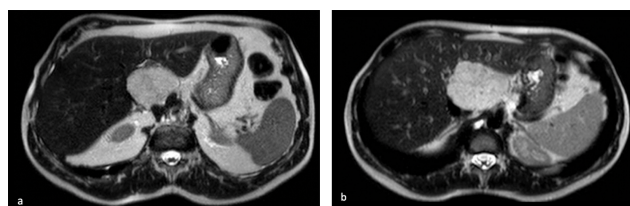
Preoperative CT-scan. (a) Case 1 MRI showing a GLH of CL (89 mm × 59 mm × 52 mm) in contact with IVC and the portal vein. (b) Case 2 MRI displaying a GLH of S-I WITH A diameter of 88 mm and signs of IVC compression.
